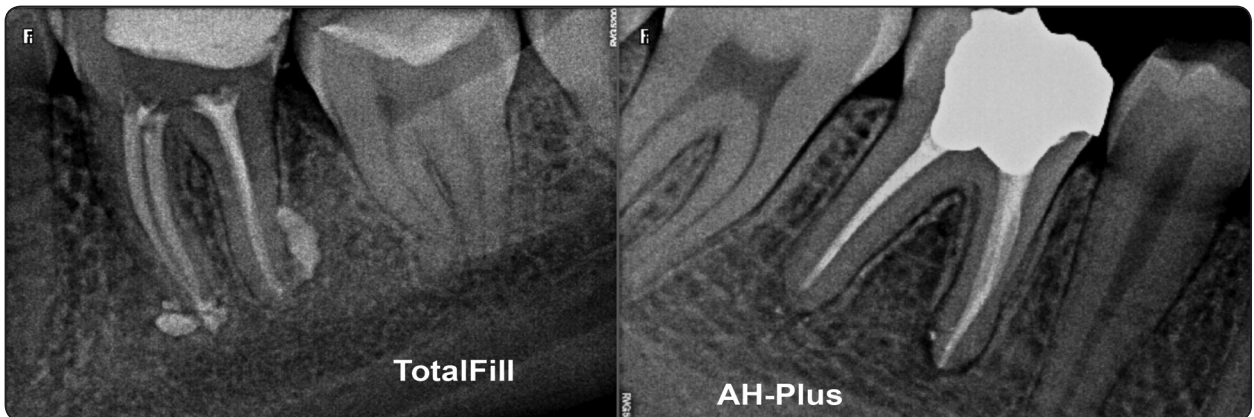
One-year post-obturation recall radiographs for cases with extruded TotalFill (Lt.) and AH-Plus (Rt.) sealers. Notice the high resorption rate of the extruded AH-plus with incomplete healing compared to TotalFill.
